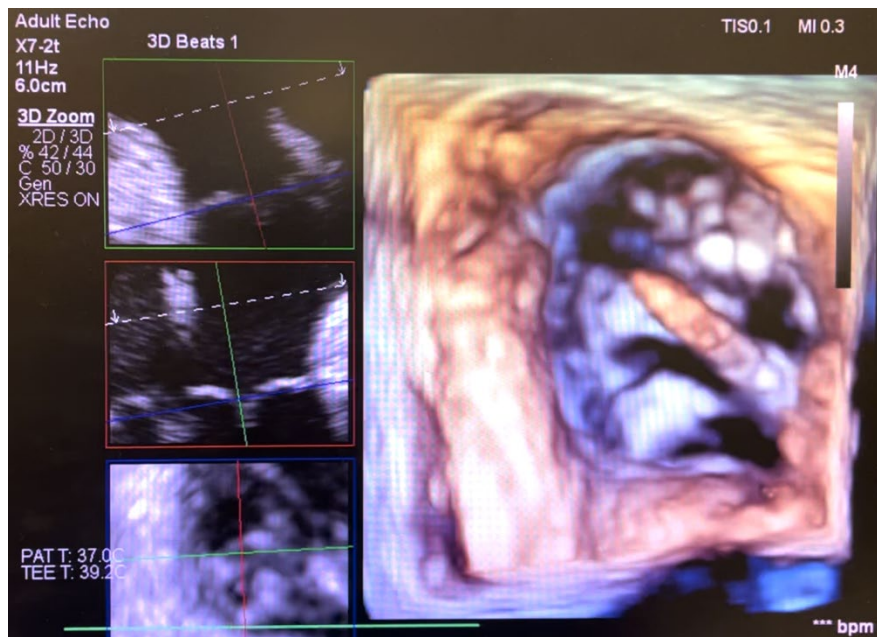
Transesophageal echocardiogram showing thrombosed cast of the RA inflow cannula extending from the right atrium, through the mitral valve, into the right ventricle
